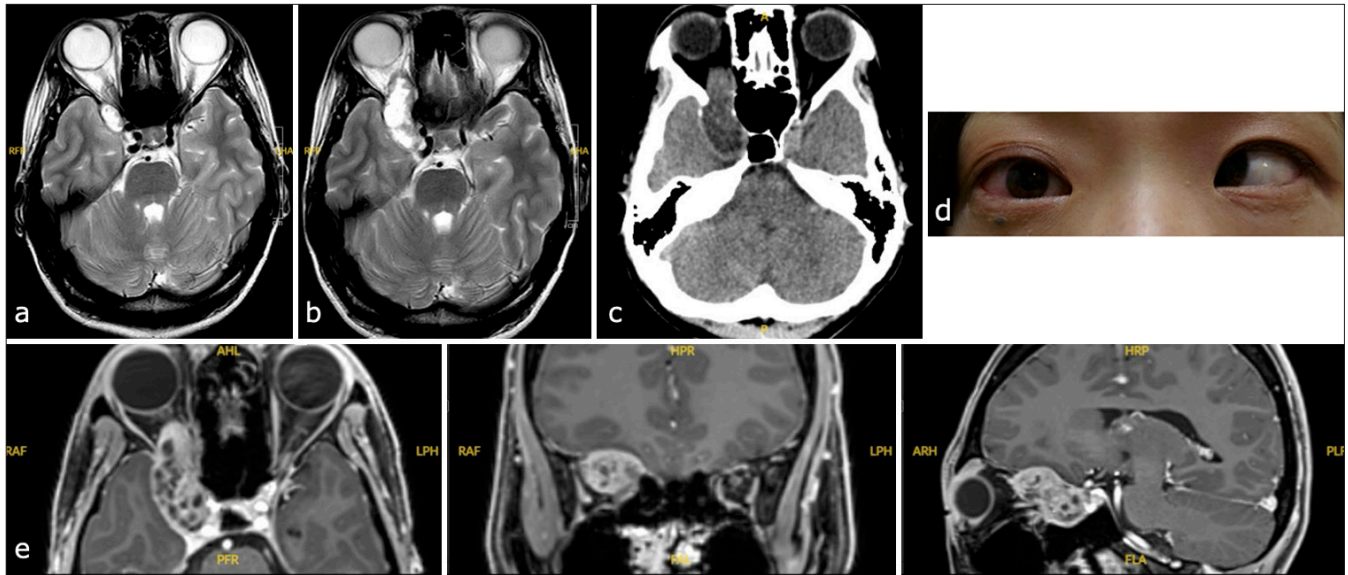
(a) Initial magnetic resonance T2-weighted imaging of the tumor. (b) The tumor grew rapidly during pregnancy and extended to the intraorbital area. (c) Head computed tomography showing the enlargement of superior orbital fissure. (d) At the last trimester, the patient developed right abducens palsy and a mildly dilated pupil. (e) Preoperative Gadolinium-enhanced T1 imaging of the tumor in axial, coronal, and sagittal views from left to right.
